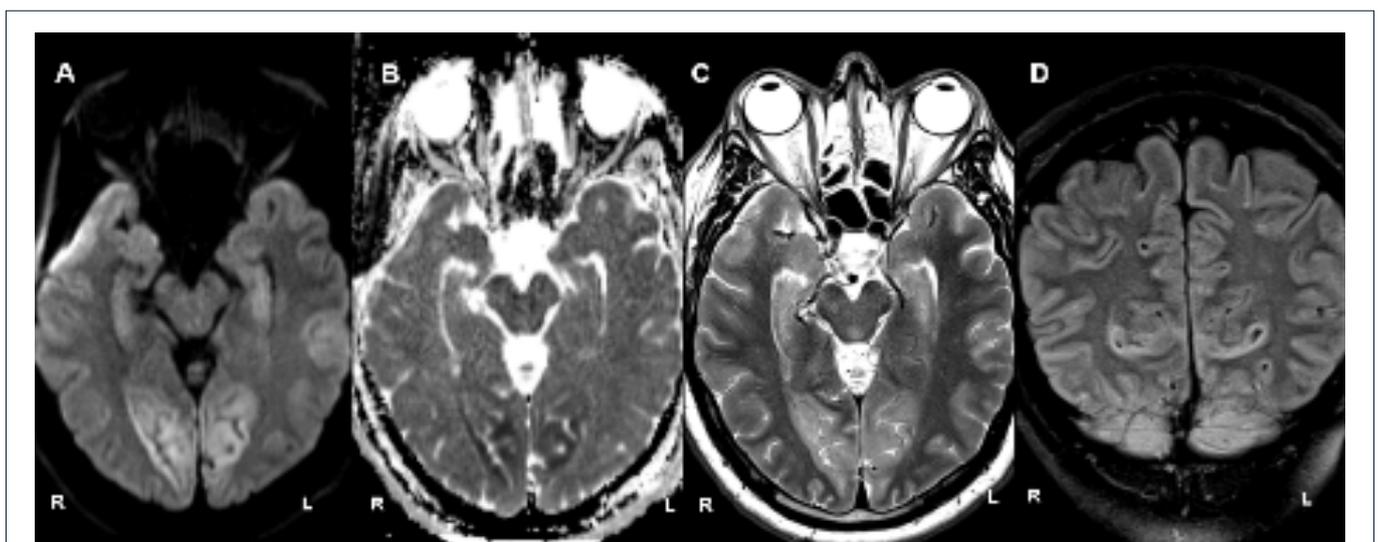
Axial diffusion-weighted imaging (a), apparent diffusion coefficient (b), T2-weighted (c), and coronal fluid-attenuated inversion recovery (d) MRI obtained 3 days after cardiac arrest demonstrate bilateral calcarine cortex signal abnormalities
